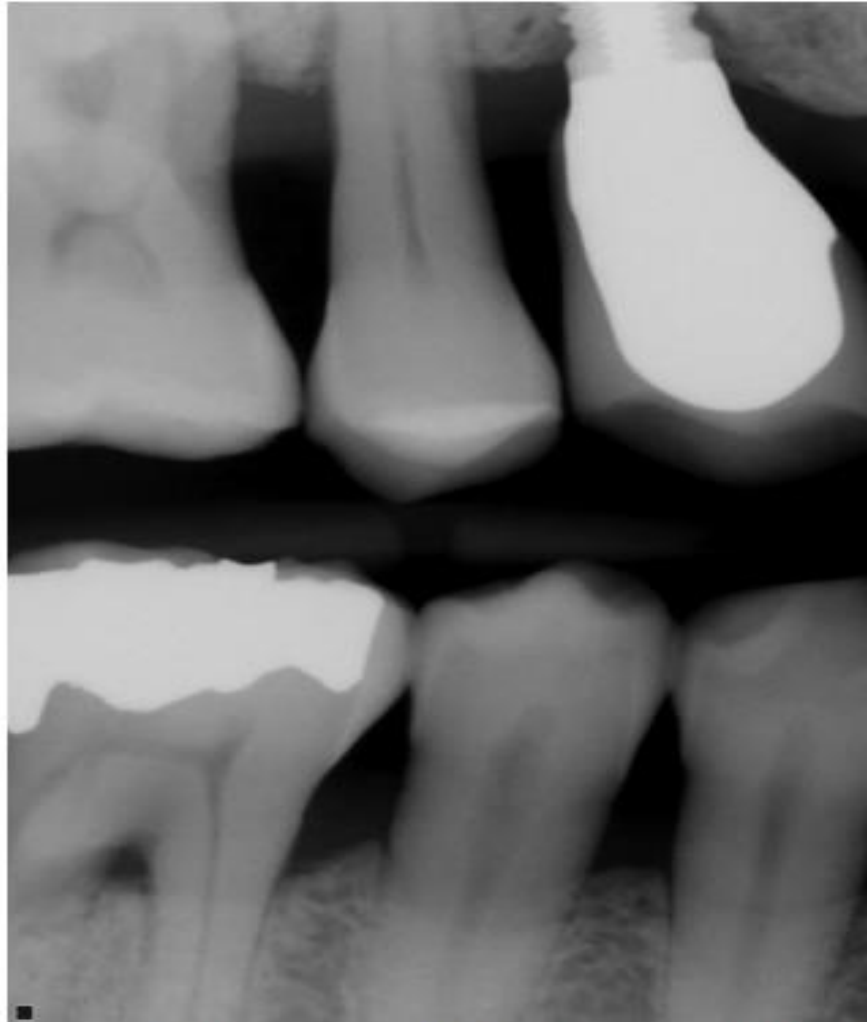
Stage 3 Periodontal Disease (mandibular + maxillary right posterior) bitewing radiograph: Radiographic bone loss extending to the middle third of root and beyond. Furcation involvement class II and class III. Image provided by authors.
